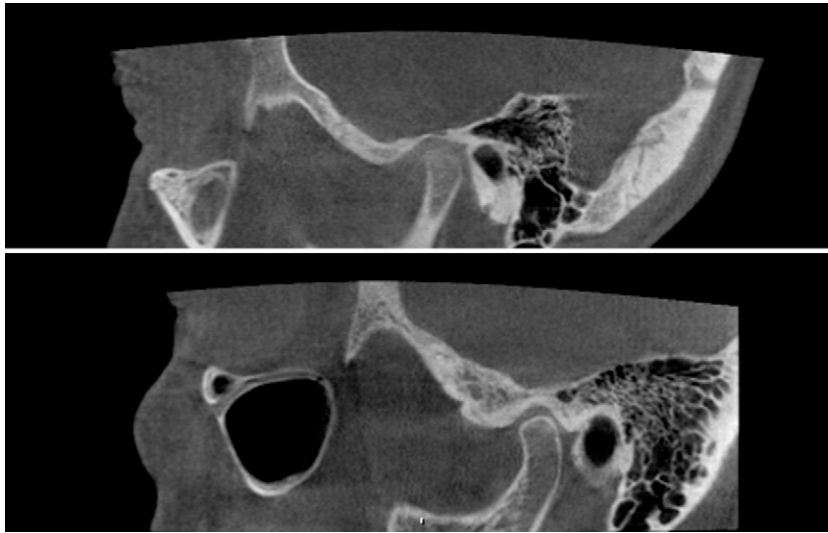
CBCT of normal temporomandibular joint (?): non-compact, non-homogeneous cortical surface of condyle (upper), making diagnostic assessment uncertain (female, 13 years). Normal compact and homogeneous cortical outline of condyle (lower) for comparison (female, 69 years).
